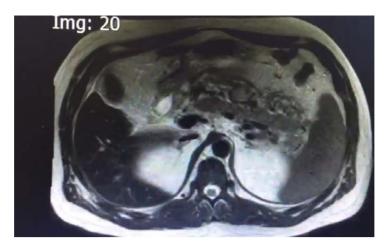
Magnetic Resonance imaging. Extensive necrotic collection spreading from the head to the tail of the pancreas.
